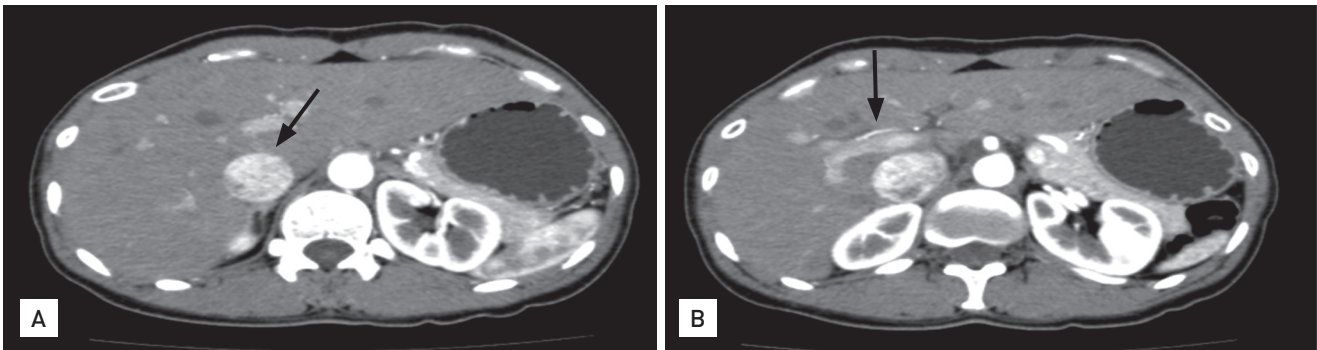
Abdominal computed tomography findings revealed no parenchymal liver disease or obstruction of the hepatic vein. Dilatation of the inferior vena cava (black arrow, A) and engorgement of the hepatic vein (black arrow, B) are shown.
